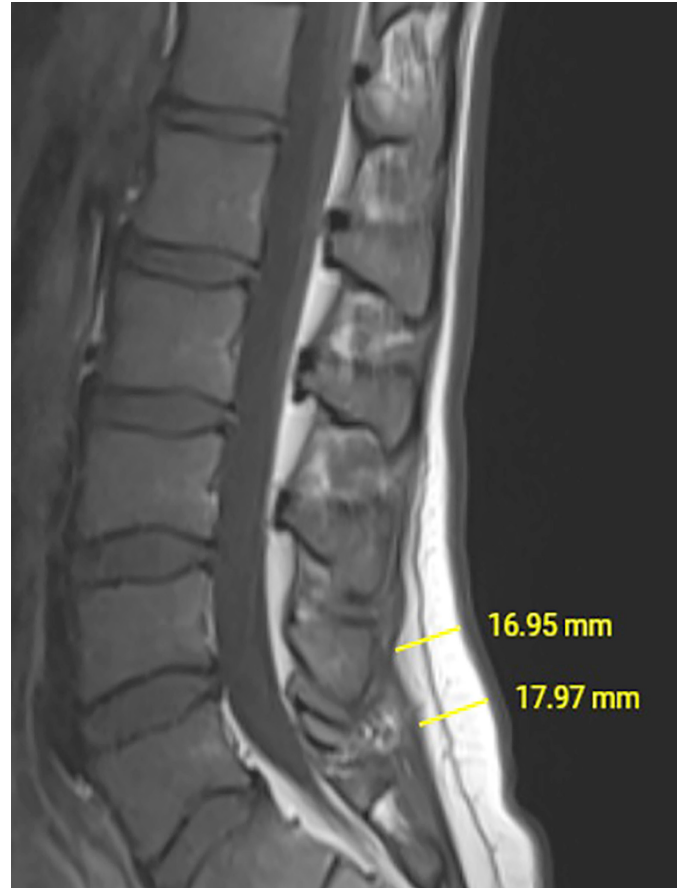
The dorsal subcutaneous fat thickness was measured on sagittal T1-weighted images as shown in the figure.
